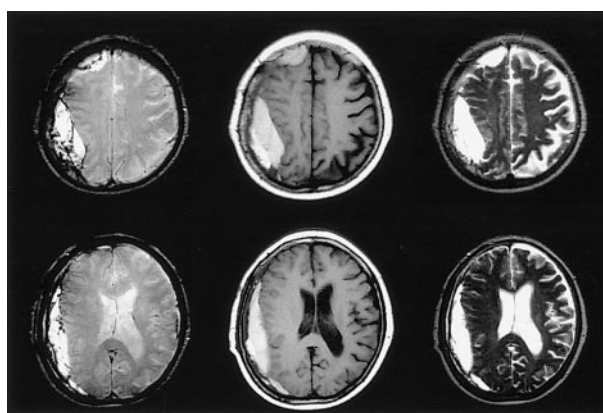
MR image of a 67-year-old woman with what was considered to multilayer hematoma and classified as type C; (left) T_2^* -weighted image, (center) T_1 -weighted image, (right) T_2 -weighted image
